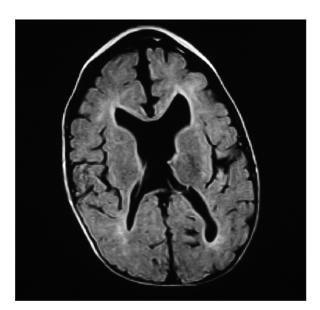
Brain fluid-attenuated inversion recovery (spin echo: echo time, 105.0 msec; repetition time, 9000 msec) magnetic resonance imaging of the brain at 5 years old.
